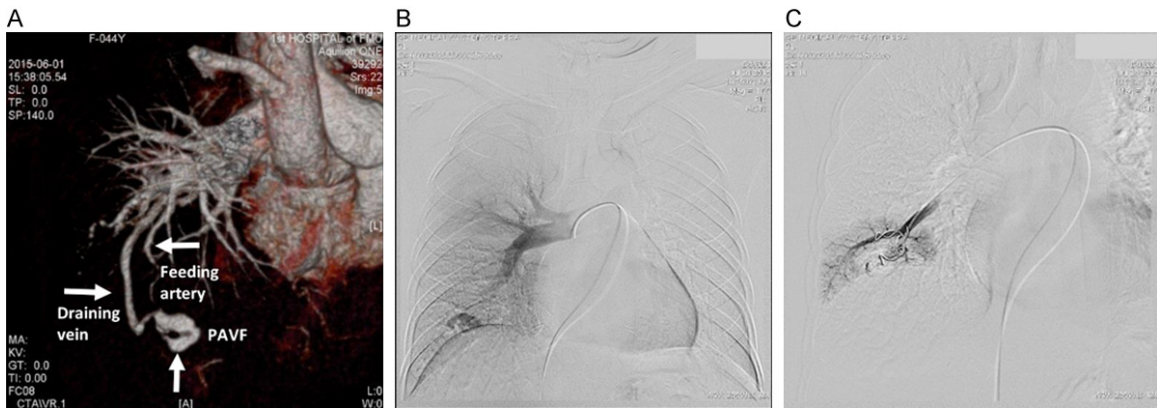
(A) Pulmonary CT angiography showed a single PAVF approximately 1.78 cm × 1.72 cm in size (†) with the feeder (←) and drainer (→) blood vessels in the right lower lobe. (B, C) Fluoroscopy showed the arteriovenous fistula before (B) and after (C) coil embolization.
